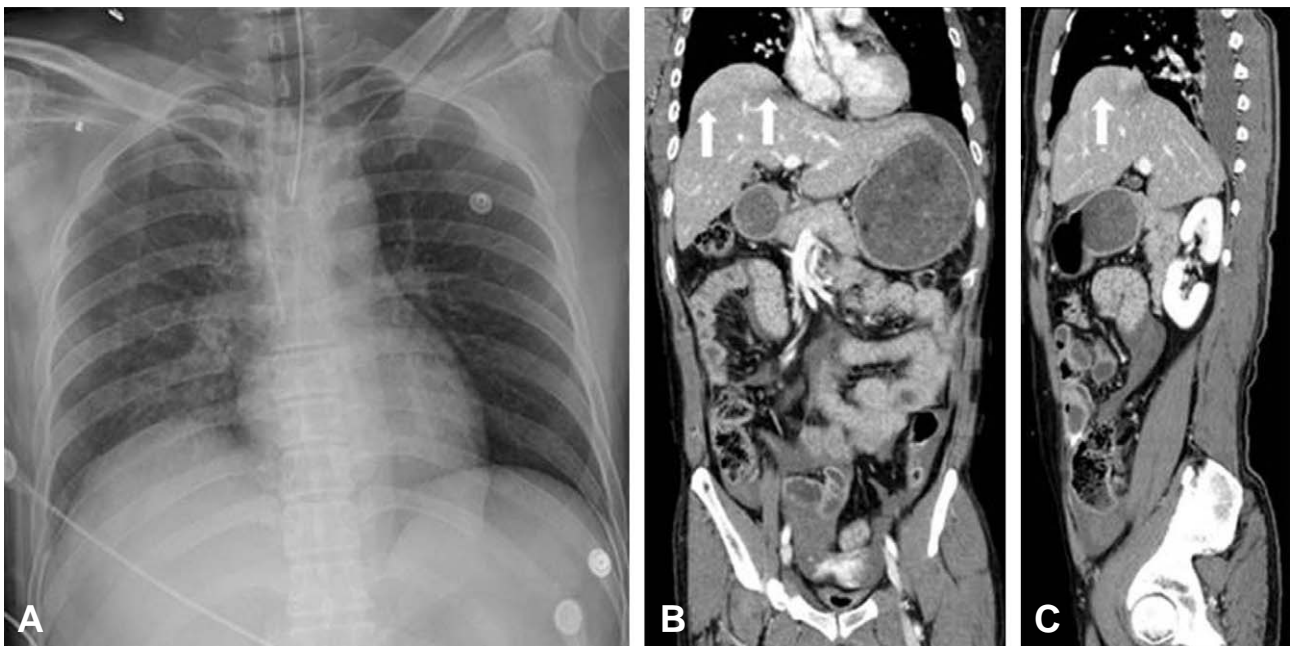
Anterolateral chest x-ray at admission (A), abdominal CT showing suspected rupture (arrows) of the right hemi-diaphragm on sagittal (B) and coronal (C) views.
